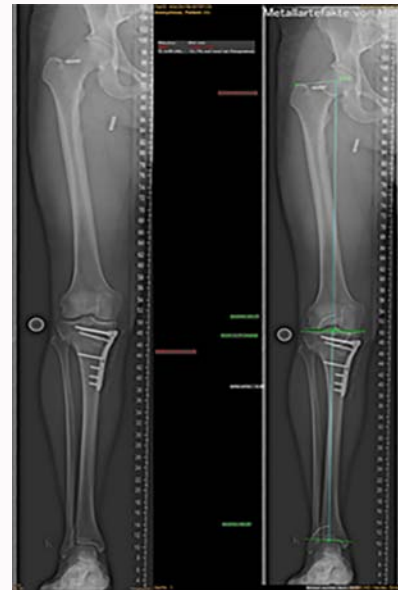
A postoperative full-length weight-bearing radiograph showing the mechanical axis of the right knee corrected to the neutral alignment.
